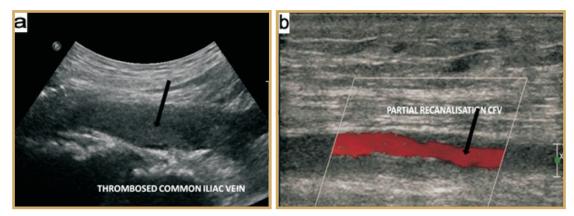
(a-b) : Thrombosed common iliac vein on doppler study. Partial recanalization seen in (a) common femoral vein and (b) superficial femoral vein after treatment on doppler study.
